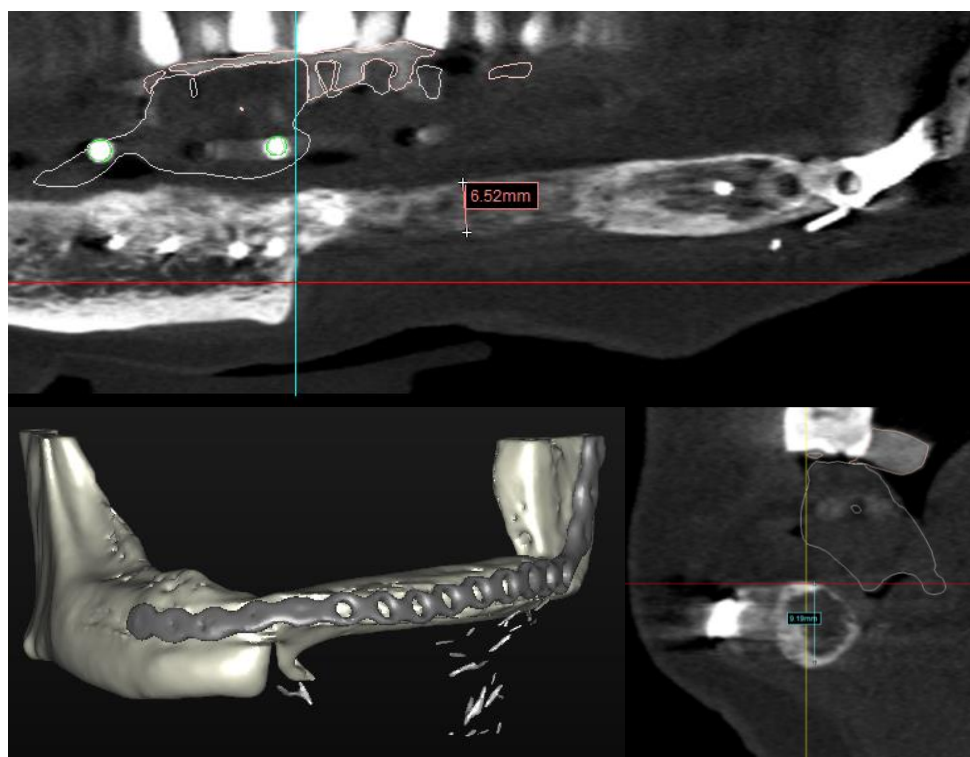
CBCT imaging of fibula free flap being used to assess and confirm in this instance a lack of bone height to accommodate implant placement.
